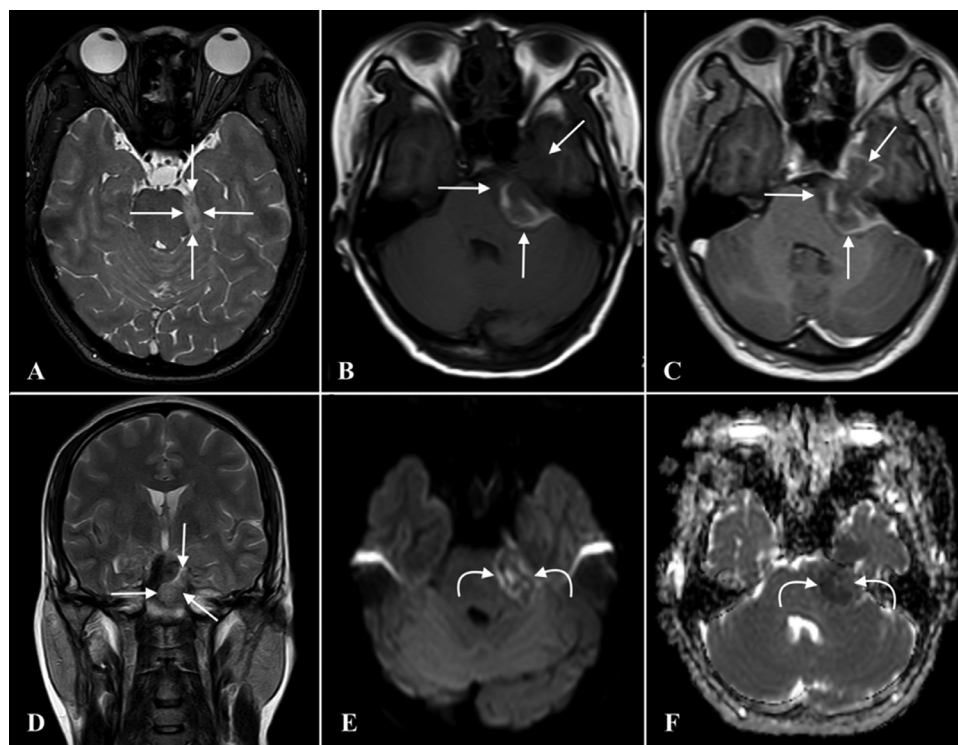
The preoperative brain MRI. It showed a left cerebellopontine angle extra-cranial lesion extending into Meckel's cave and the middle cranial fossa. (B) Peripheral hyperintensity and central hypointensity in axial postcontrast T1W axial images corresponding to peripheral hypointensity and central hyperintensity in T2W (A) axial and (D) coronal images (straight arrow). (C) Postgadolinium T1W images show heterogeneous contrast enhancement with a solid enhancing component in the middle cranial fossa. Heterogeneous diffusion restriction areas are observed on the (E) DWI and (F) ADC map (curved arrow).
